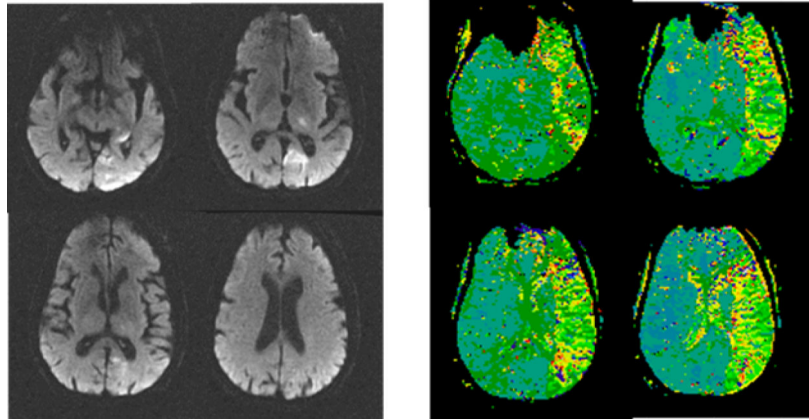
DWI (left) and PWI (right) of Case 5 with impaired d' score for phoneme discrimination at Day 1. Bright areas on DWI (left) are areas dense ischemia/infarct. Yellow/green areas on PWI (right) are areas of significant hypoperfusion (>4 sec delay in TTP)
